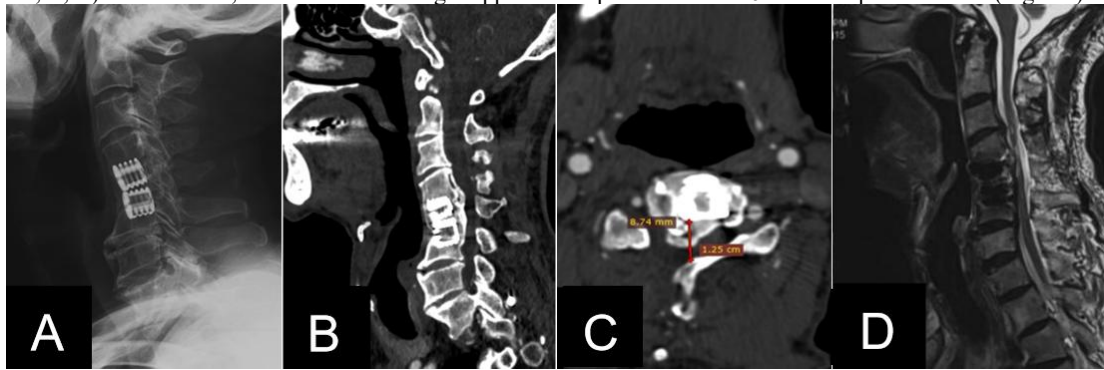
Preoperative Head and Neck Imaging: X-ray, CT, and MRI Images of the Patient.
